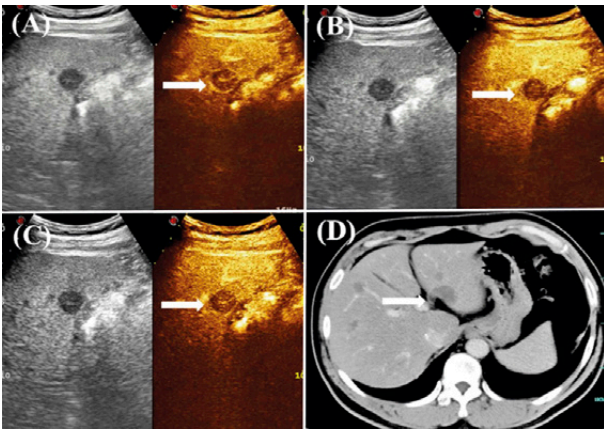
HEHE in a 42-year-old female with elevated CA125 (541.2 ng/ml), negative hepatitis B and AFP: (A) CEUS observation of circumferential enhancement in the right liver lesion at 24 s in the dynamic phase, with uneven hypo-enhancement inside; (B) CEUS reveals hypo-enhancement in the portal venous phase at 61 s; (C) CEUS shows hypo-enhancement in the delayed phase at 123 s; and (D) CT image shows multiple lesions in the liver in the delayed phase.
